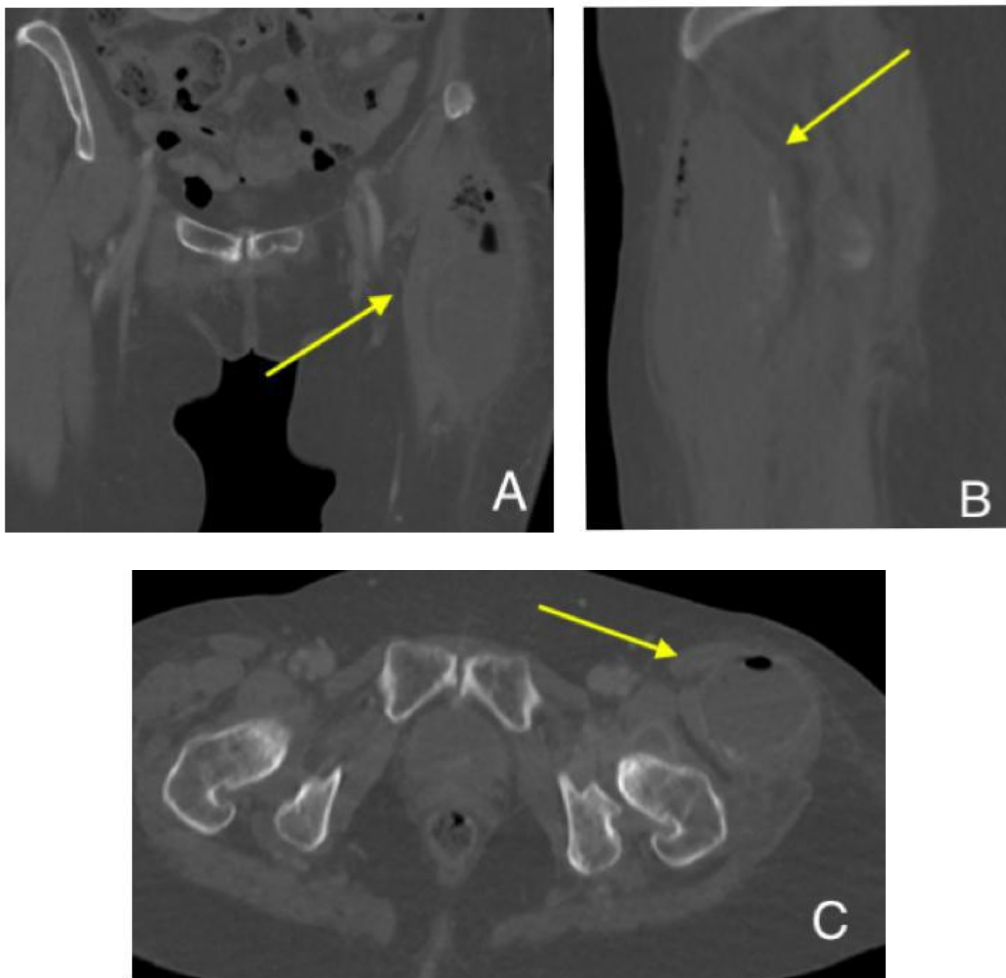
CT scan showing soft tissue collection at the level of the left hip. (A) Coronal, (B) sagittal, and (C) axial slices
